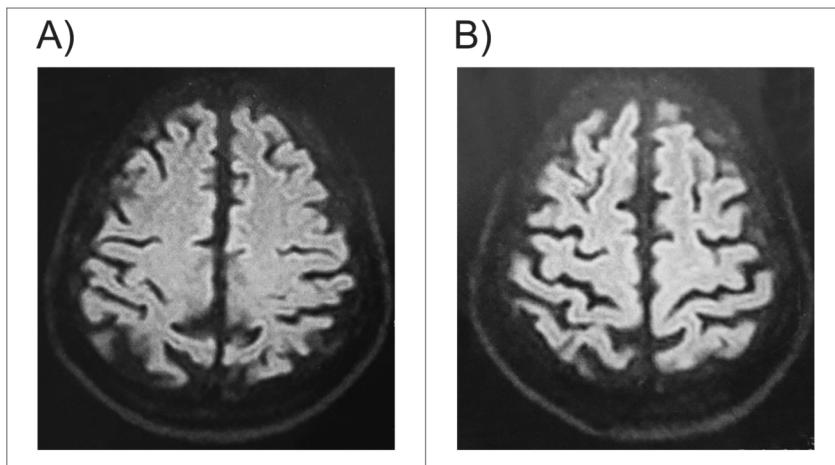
Axial CT brain MRI showing posterior cortical atrophy
